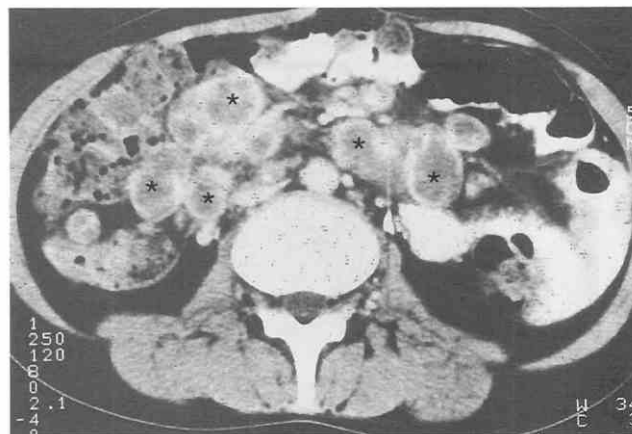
Abdominal tuberculosis with mesenteric lymphadenitis. Diffusely enlarged lymph nodes with central hypoattenuation (asterisks) are noted in the mesentery. (From Ha HK, Jung JJ, Lee MS, et al: CT differentiation of tuberculous peritonitis and peritoneal carcinomatosis. *AJR Am J Roentgenol* 167:743-748, 1996.)
